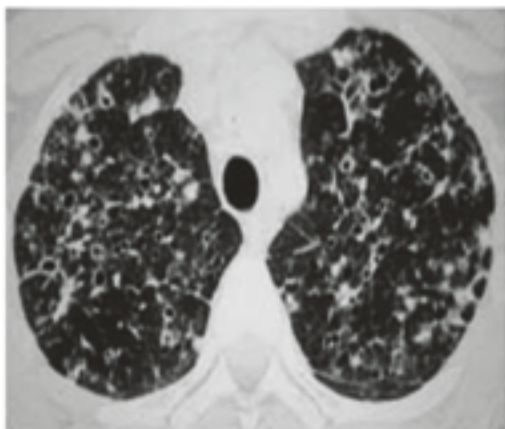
HRCT images in PLCH
